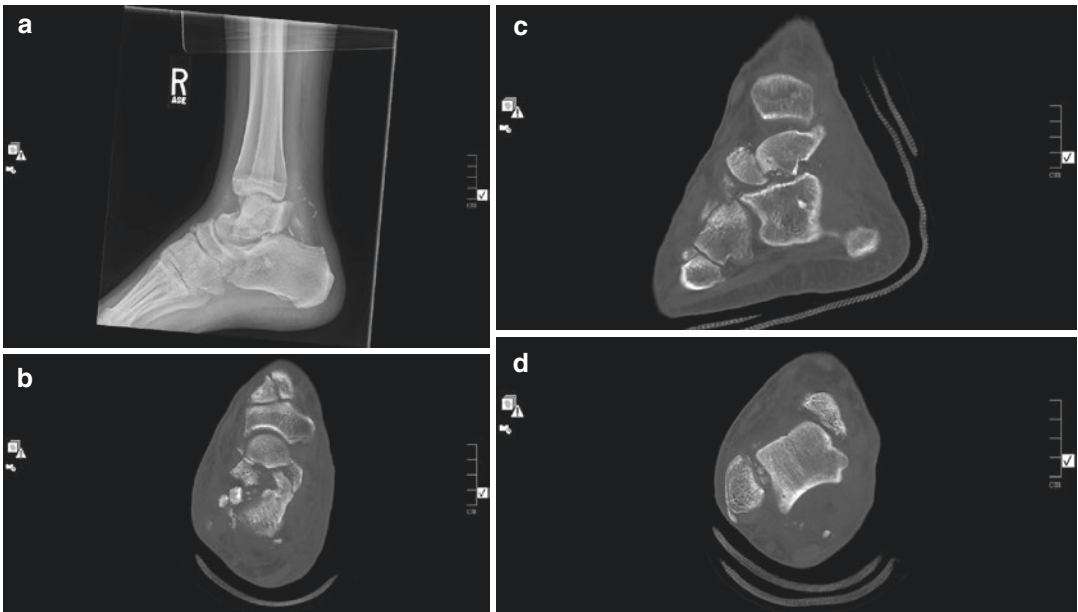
(a–d) Lateral radiograph, axial and coronal CT images of a displaced talar neck fracture with dislocations of the tibiotalar and subtalar joints
